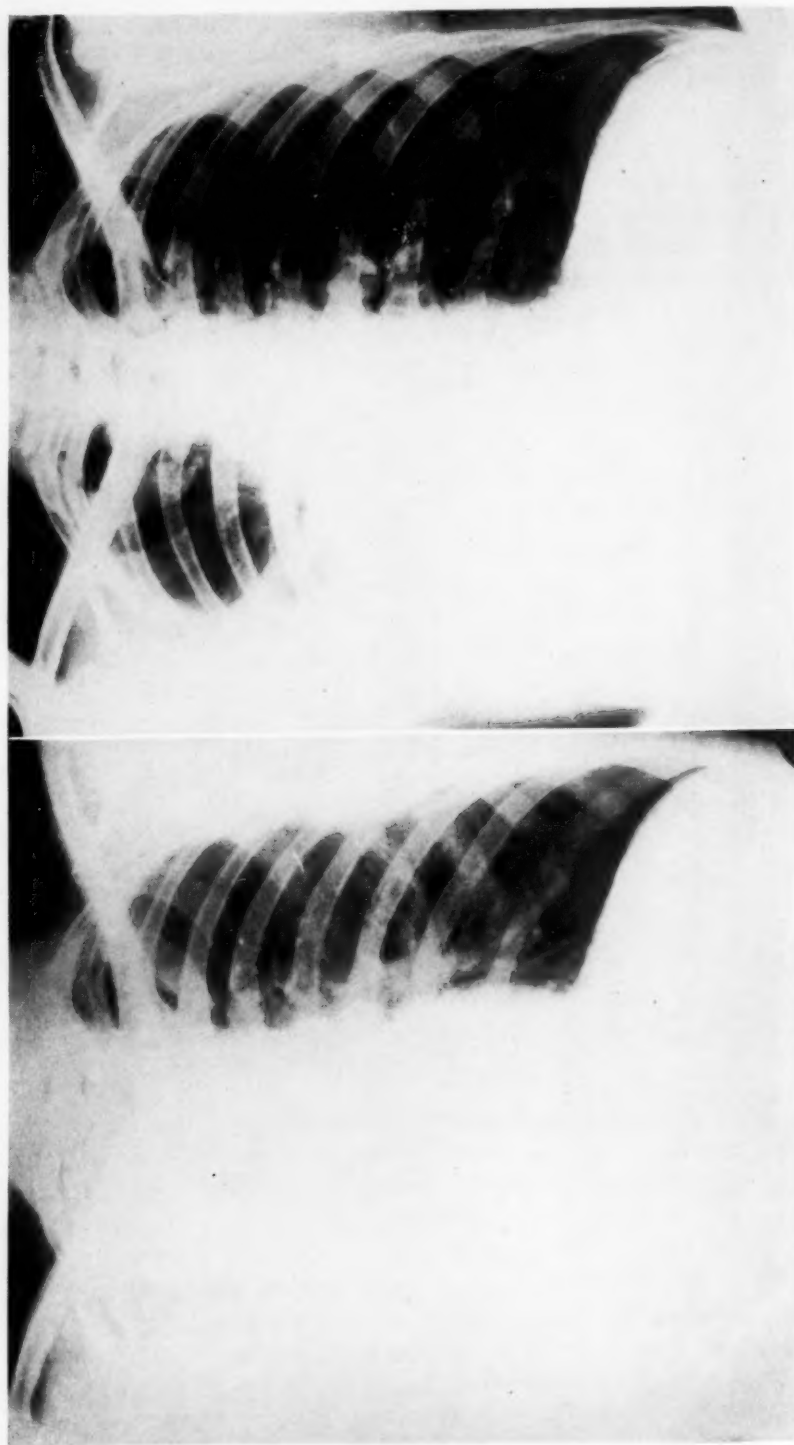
Case CS 32, pleurisy with effusion. Radiographs (left) at time of first studies, and right at time of second studies.
